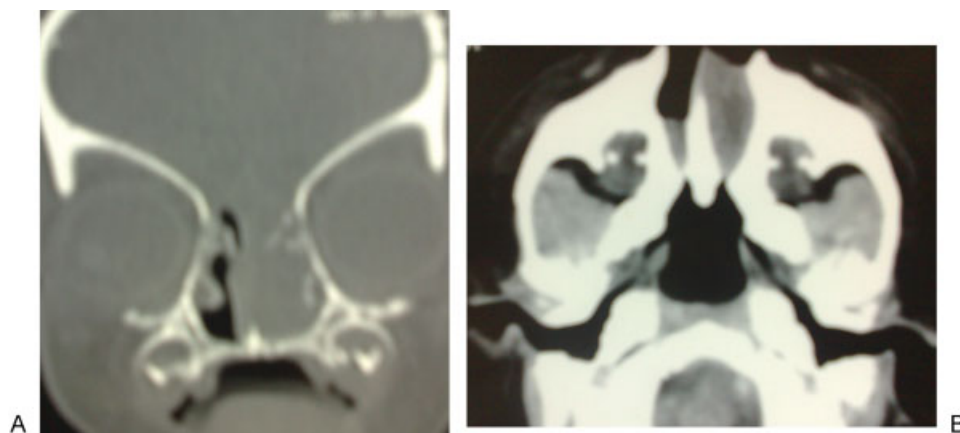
Another case, A; Coronal CT showed soft tissue density in the nasal cavity appeared continuous with the brain parenchyma due to lack of ossification of the floor of the anterior cranial fossa. B; Axial CT showed bilateral choanal atresia appeared thick due to accumulated secretion in front.
